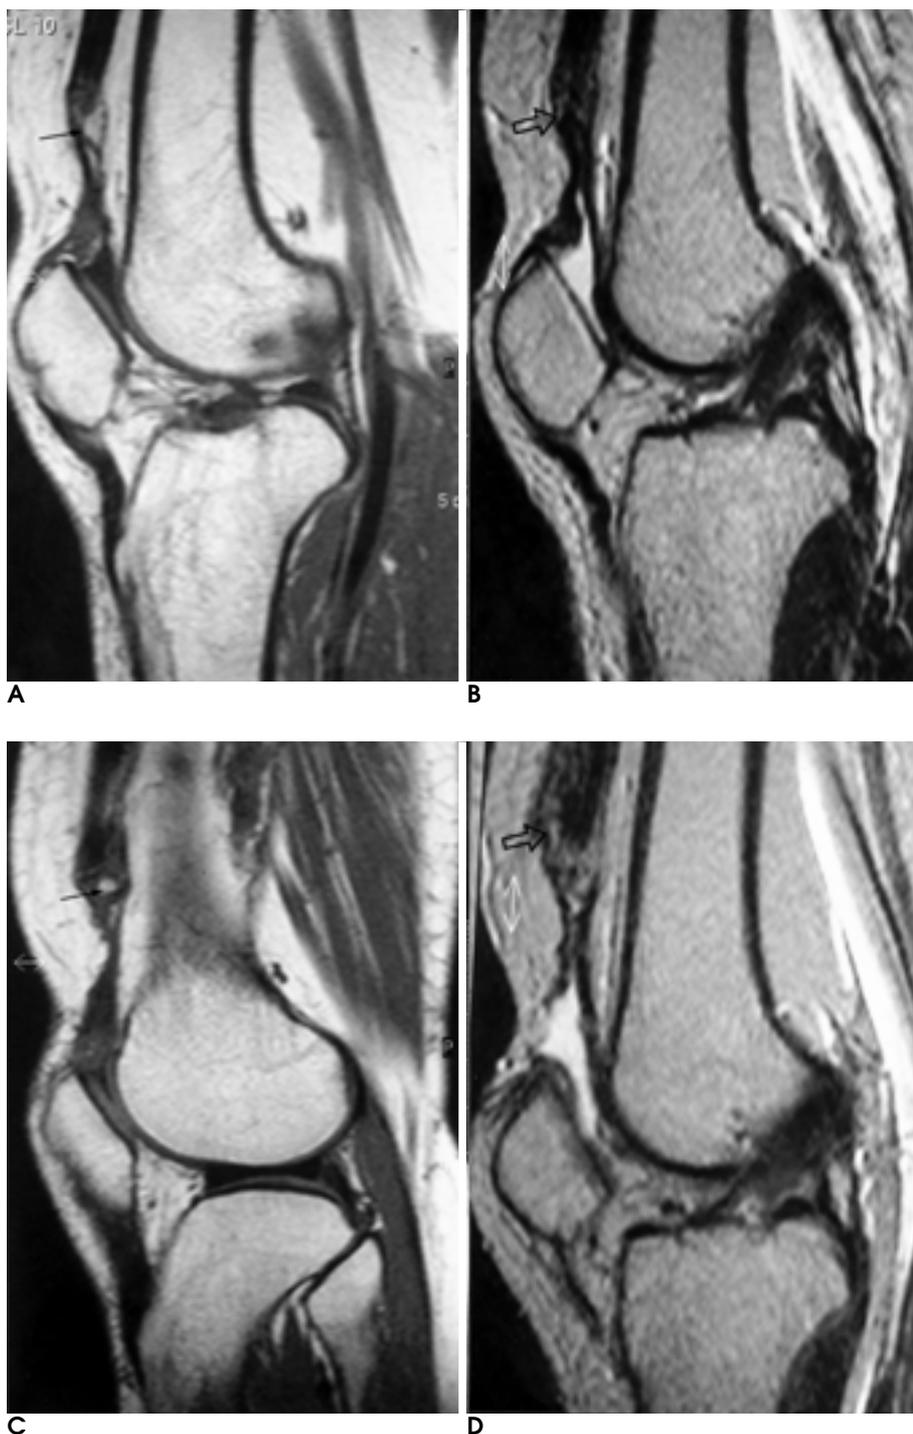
Sagittal T1- and T2-weighted MR images of the right (A, B) and left (C, D) knees reveal disruption of the quadriceps tendons from the superior pole of the patella and proximal retraction of the torn quadriceps tendon (open arrows) including focal ossified fragments (arrows). Suprapatellar fibrous tissue and hemorrhage are also noted.
